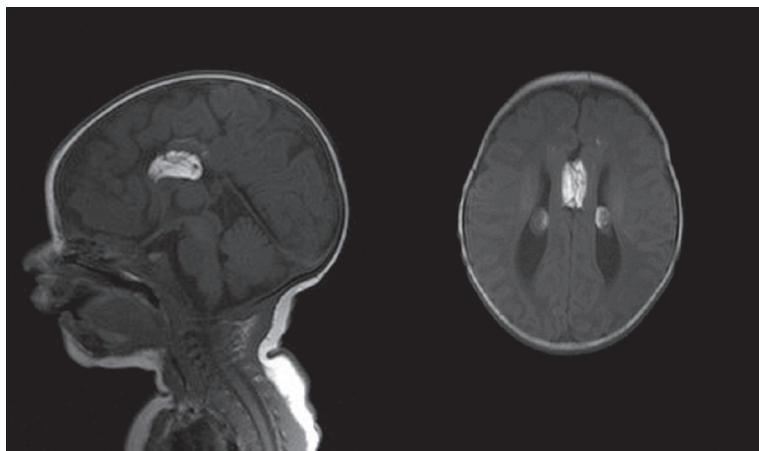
Corpus callosum lipoma and intraventricular lipomas – MRI scan (patient 2).
